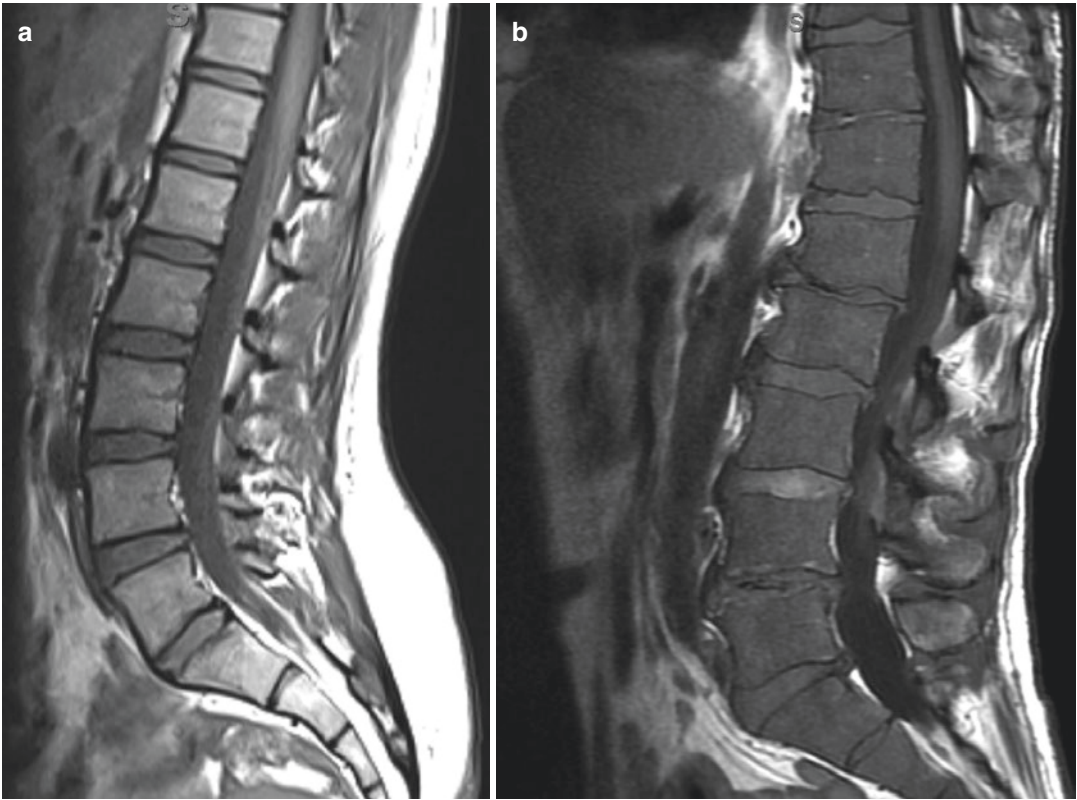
(a) T1-weighted image demonstrating normal fatty bone marrow. (b) T1-weighted image in a different patient shows replacement of the normal fatty marrow.
